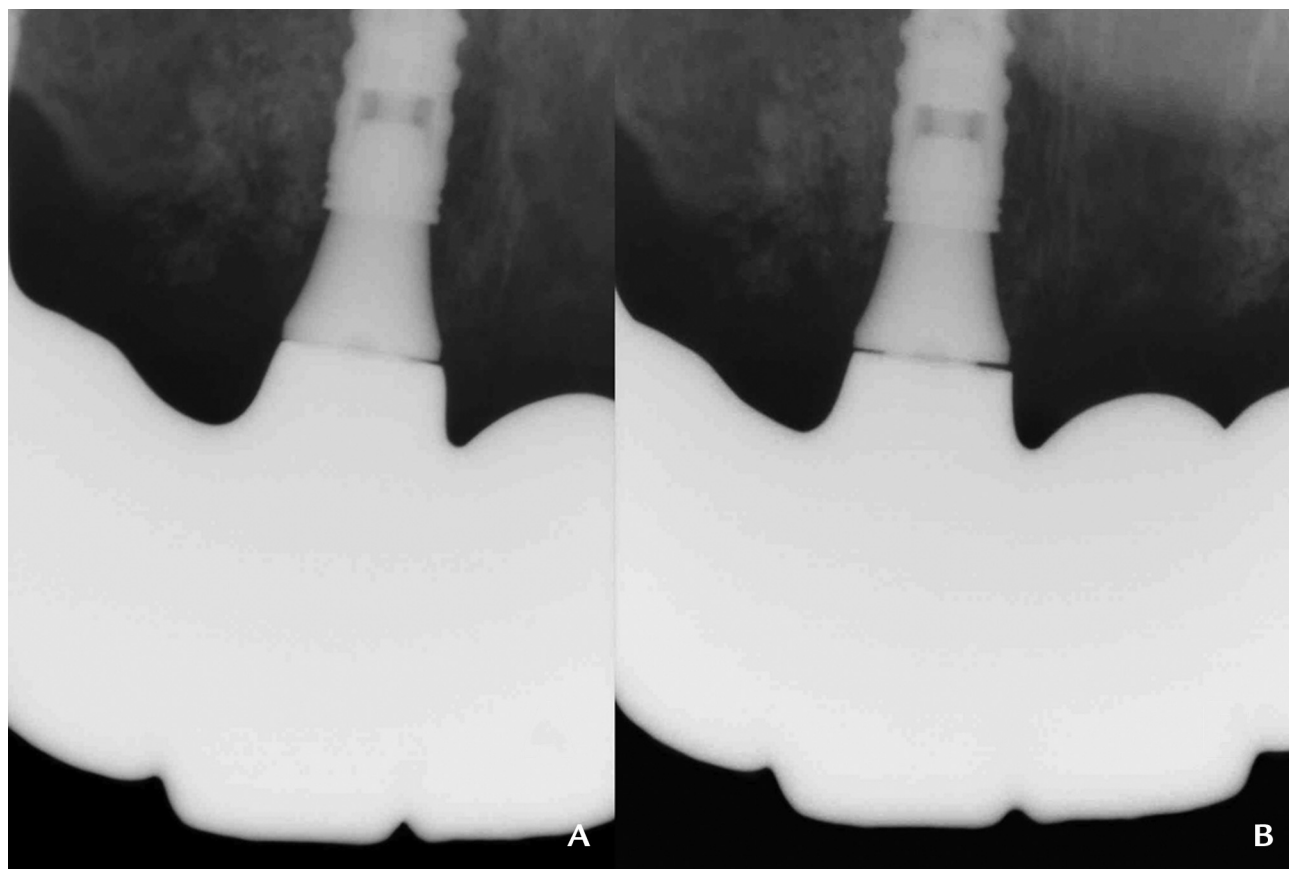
Radiographic assessment of misfit. Although radiographic guide used, perfect alignment of radiographic beam not always possible. A, Digital framework with better fit. B, Conventional framework.
